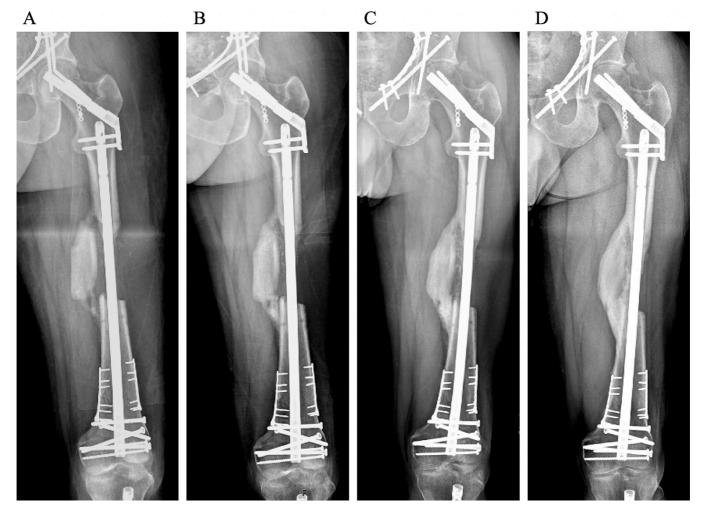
Interval fracture healing shown on anteroposterior x-rays taken at 2 months post-op (A), 3 months post-op (B), 6 months post-op (C), and 13 months post-op (D) clinic visits. X-ray at 13 months (D) demonstrated intact hardware and well-healed femoral neck, diaphyseal, and distal femur fractures.
